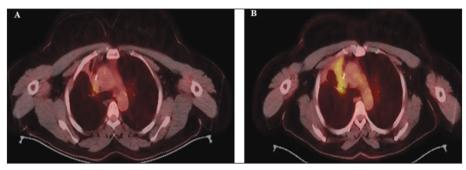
A) FDG-PET/CT sections showing lung carcinoma in remission at 12 months of afatinib therapy. B) FDG-PET/CT section showing progressive lung carcinoma four months after discontinuation of afatinib therapy. FDG-PET/CT: Fluoro-D-glucose-positron emission tomography/computed tomog.
